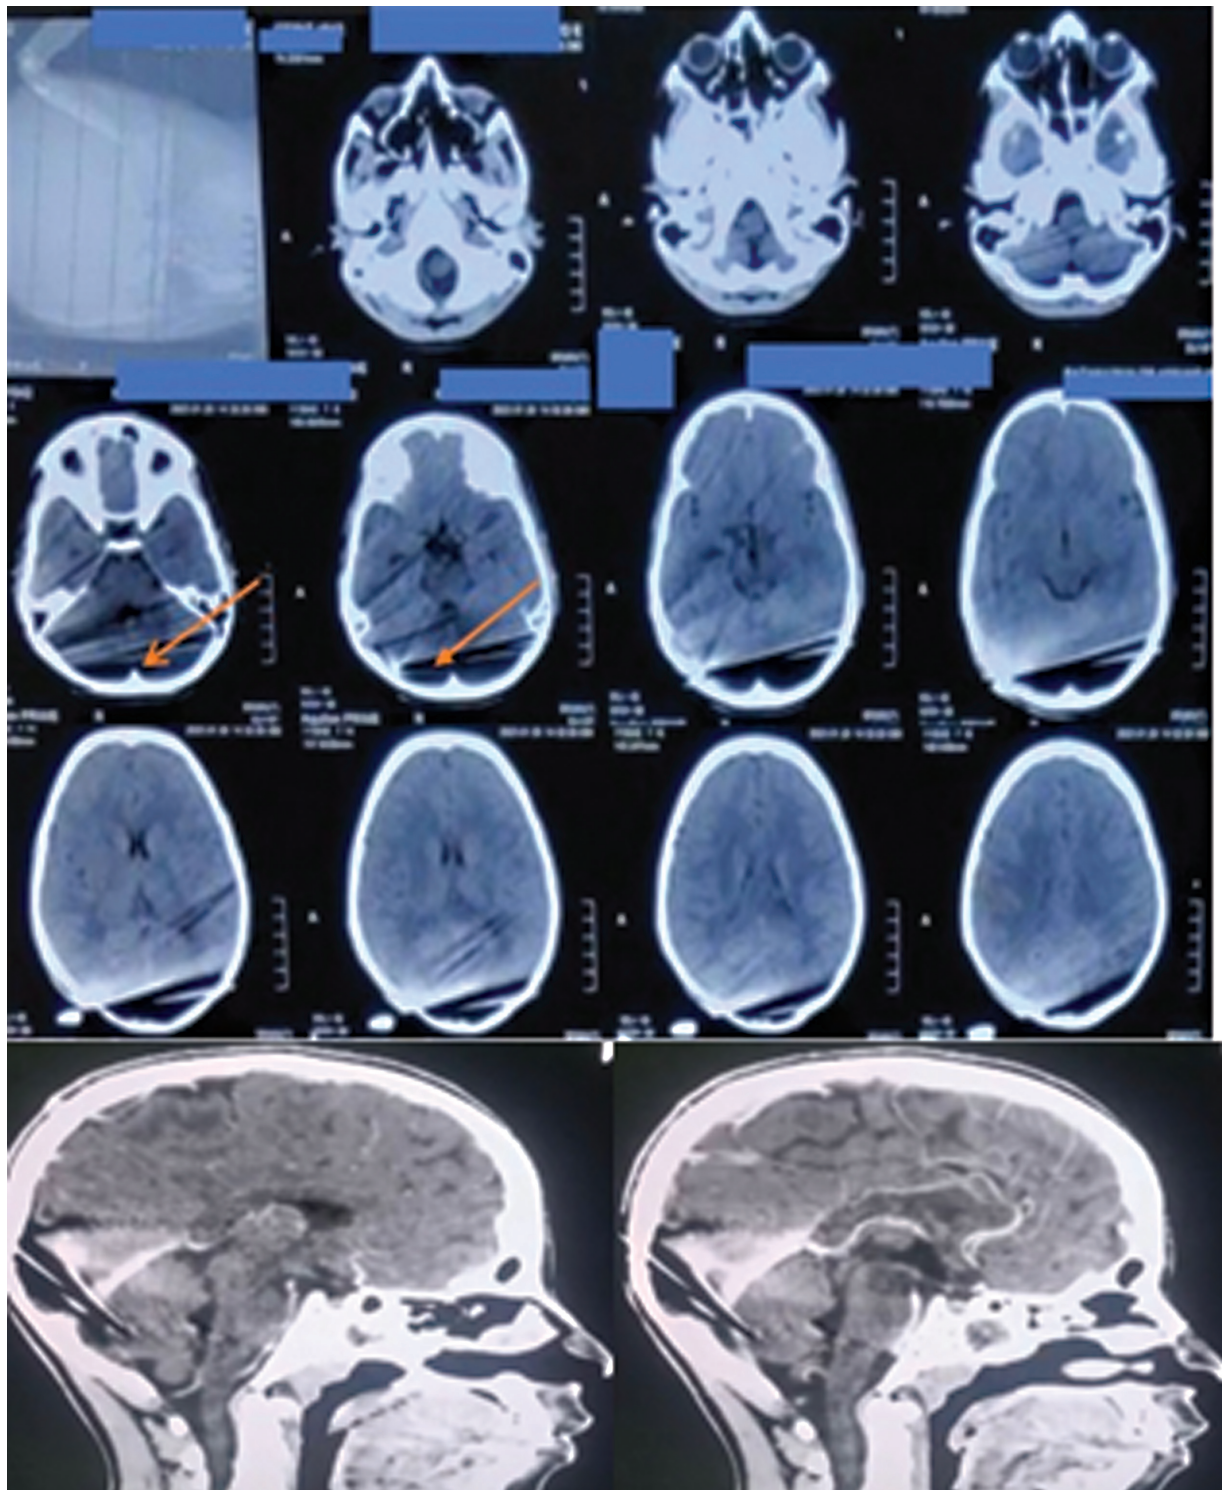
Computed tomography (CT) of the brain showing knife blade in the occipital bone with the corresponding metal streak artifact with CT venogram sagittal view.
